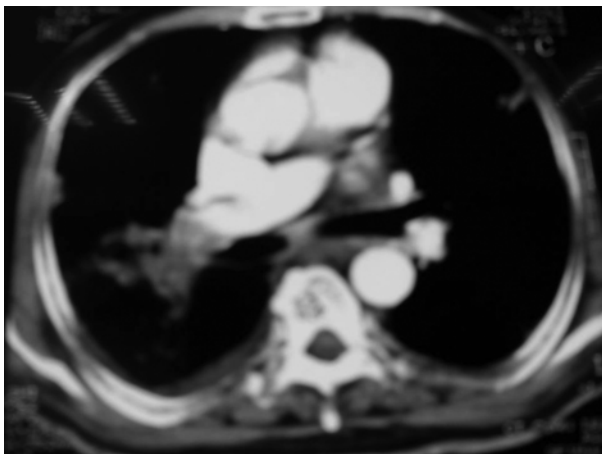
Chest CT-scan of patient.
